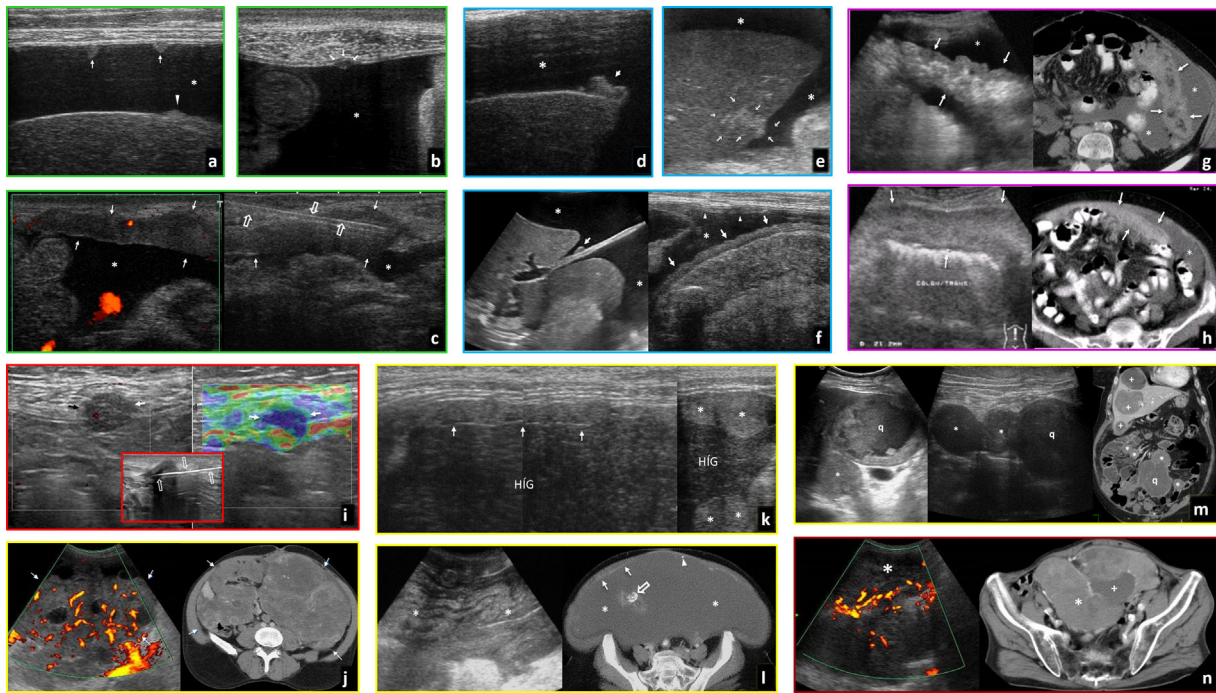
Peritoneal and subperitoneal neoplasms. Green box: parietal peritoneum. Blue box: visceral peritoneum. Purple box: greater omentum. Red box: invasion of wall. Yellow box: other types of cancer. Brown box: subperitoneal mesenchymal tumours. A) Ovarian cancer. Very small implants in the parietal peritoneum (arrows) in the presence of ascites (*). Small implant in the hepatic visceral peritoneum (arrowhead). B) Stomach cancer. Very small peritoneal implant (arrows) invading the *fascia transversalis* and the right anterior rectus muscle of the abdomen (there is no deep muscle fascia below the arcuate line) in the presence of ascites (*). C) Ovarian cancer. Linear thickening of the parietal peritoneum (arrows) and ascites (*). Ultrasound helps guide the biopsy of the smooth thickening of the peritoneum (empty arrows). D) Bladder cancer. Nodular implant in the hepatic visceral peritoneum, without parenchymal invasion (arrow) and ascites (*). E) Ovarian cancer. Nodular implant in the hepatic visceral peritoneum, with parenchymal invasion (arrow) and ascites (*). F) Endometrial cancer. Left image: millimetric nodular implant in the visceral peritoneum covering the extrahepatic falciform ligament (arrow). Ascitis (*). Right image: smooth thickening of the visceral peritoneum on a stretch of small bowel (arrows) and ascites (*). Smooth thickening of the parietal peritoneum (arrowheads). G) Colon cancer. Striated infiltration of the omentum (omental smudging). Thickening of the visceral peritoneum of the greater omentum and fat stranding (hypoechoic and hyperdense, respectively, in relation to the fat) (arrows) and ascites (*). H) Ovarian cancer. Diffuse infiltration of the omentum (omental cake). Diffuse infiltration of the gastocolic ligament and its continuation below the transverse colon (greater omentum) (arrows) and ascites (*). I) Colon cancer. Implant in parietal peritoneum with direct invasion of the wall (arrows), with ultrasound and qualitative elastography, without ascites. In the inset, percutaneous biopsy in another similar case (empty arrows). J) Peritoneal desmoplastic small round cell tumour. Large omental, mesenteric and peritoneal masses (arrows) with abundant vascularisation in a young male. K) Mucinous peritoneal carcinomatosis due to gastric adenocarcinoma. Perihepatic echoic covering layer (arrows) and echoic mucinous implants (*) with scalloping of the liver (LIV). L) Peritoneal adenomucinoses. Massive inframesocolic occupation by complex mucinous material (*), with alternating echogenicities and converging into a central calcification (empty arrow). The complexity of the mucinous material is reflected much better on ultrasound than computed tomography (CT). Implants with fine calcifications (arrowheads) in a thickened parietal peritoneum (arrows). M) GIST with peritoneal and hepatic spread. Numerous rounded nodular lesions in both the liver (+) and the peritoneal cavity (*), the largest with cystic and/or necrohaemorrhagic changes (q). N) GIST of sigmoid mesocolon. Doppler ultrasound and CT. Large hypervascular pelvic mass (*) with cystic or necrotic areas (+).
